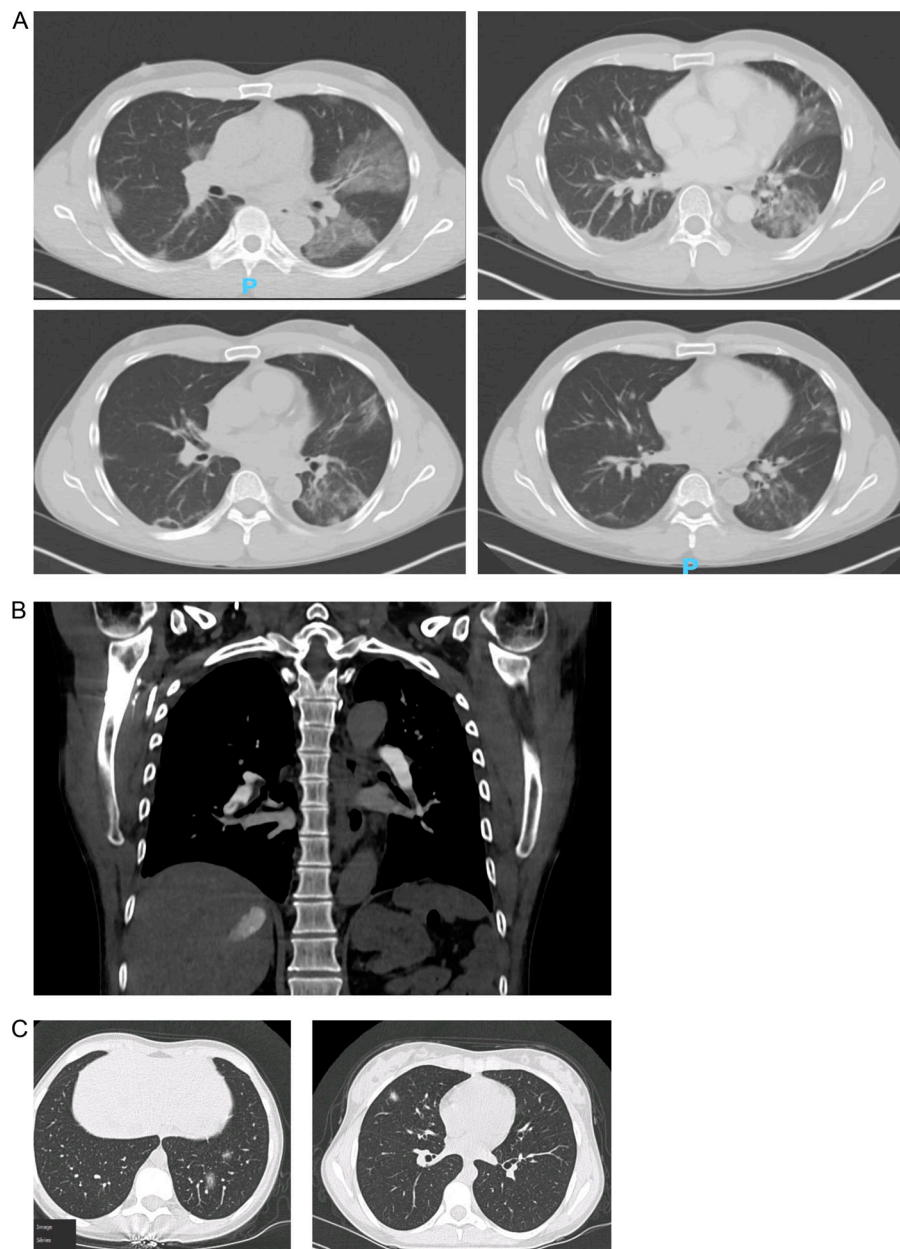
Imaging of COVID-19 pneumonia in APS-1 patients. (A) Course of COVID-19 pneumonia in an APS-1 patient. Bilateral (left to right) ground-glass opacities are seen on initial chest CT 6 d after symptom onset (left upper panel). Persistence of bilateral ground-glass opacities with a worsening of radiographical signs in the left lung base on day 10 after symptom onset (right upper panel). Improvement of ground-glass opacities on days 16 (left lower panel) and 37 (right lower panel) after symptom onset. (B) Coronal chest CT angiogram demonstrating nonocclusive segmental pulmonary embolus to the distal pulmonary arterial branches of the right lower lobe. (C) Chest CT scan of an APS-1 patient showing bilateral alveolo-interstitial lesions of COVID-19 pneumonia.
